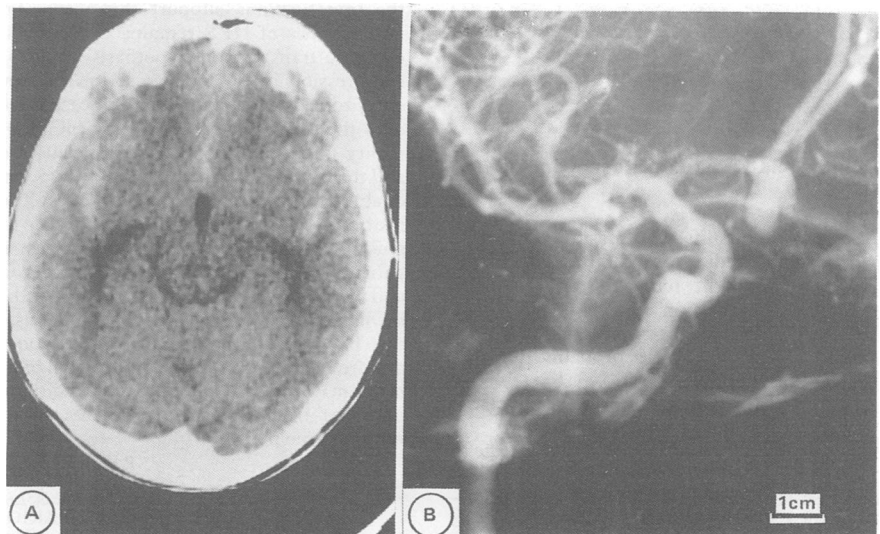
CT scan on second day showing diffuse blood interhemispherically. 1b Angiogram showing anterior communicating artery aneurysm (12 × 8 mm).
